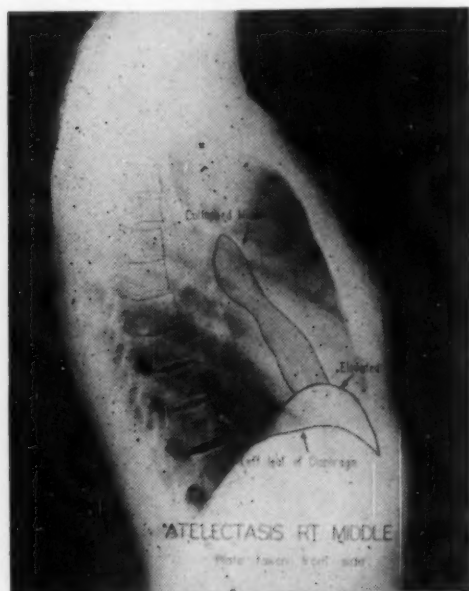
The same radiograph with its acetate overlay, made from the tracing in Figure 2, in place. Photographed by transmitted light upon an x-ray illuminator.
